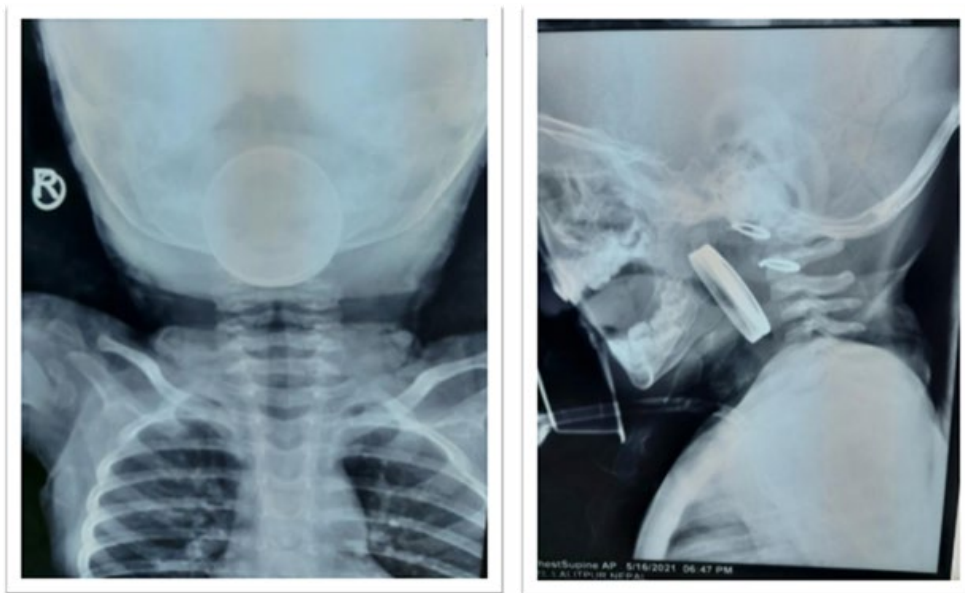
(A&B): X-ray Soft Tissue Neck Ap And Lateral View Showing Radio Opaque Foreign Body
